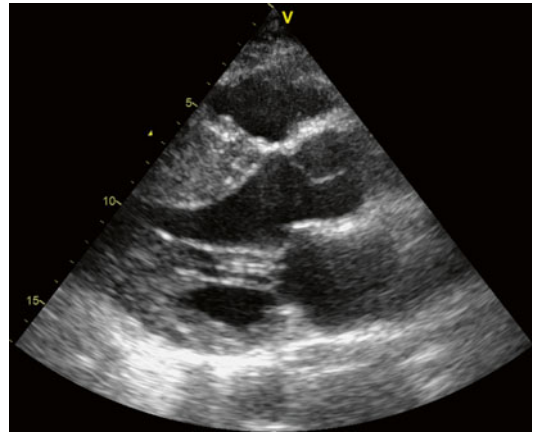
Parasternal long-axis view shows septal hypertrophy
